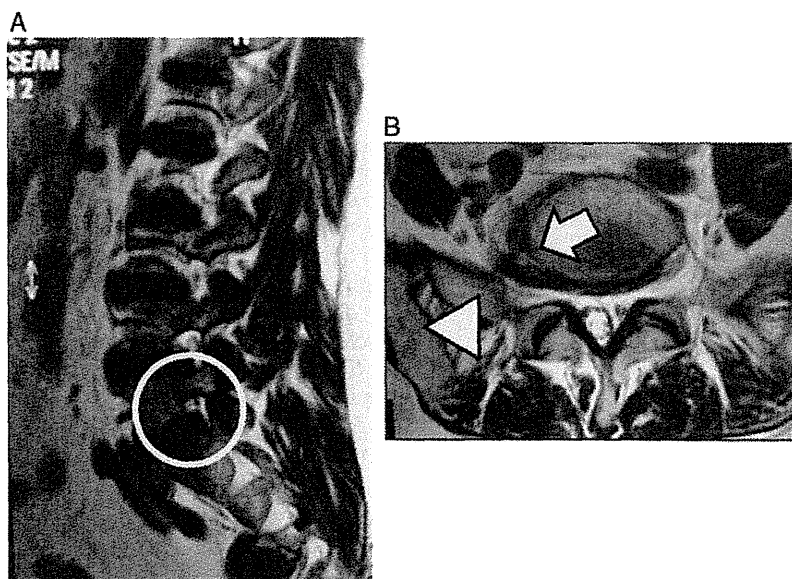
An example of conventional magnetic resonance images in case of extraforaminal stenosis at the lumbosacral junction. A, On the T2-weighted parasagittal view of right L5-S1 foramen, no obvious stenotic lesion is observed (open white circle). B, On the axial view at the level of L5-S1 segment, although the existence of bony stenosis between the posterolaterally developed bony spur of L5 vertebral body (white arrow) and the sacral ala (white triangle) is suspected on the right, it is difficult to determine whether there is nerve compression.
